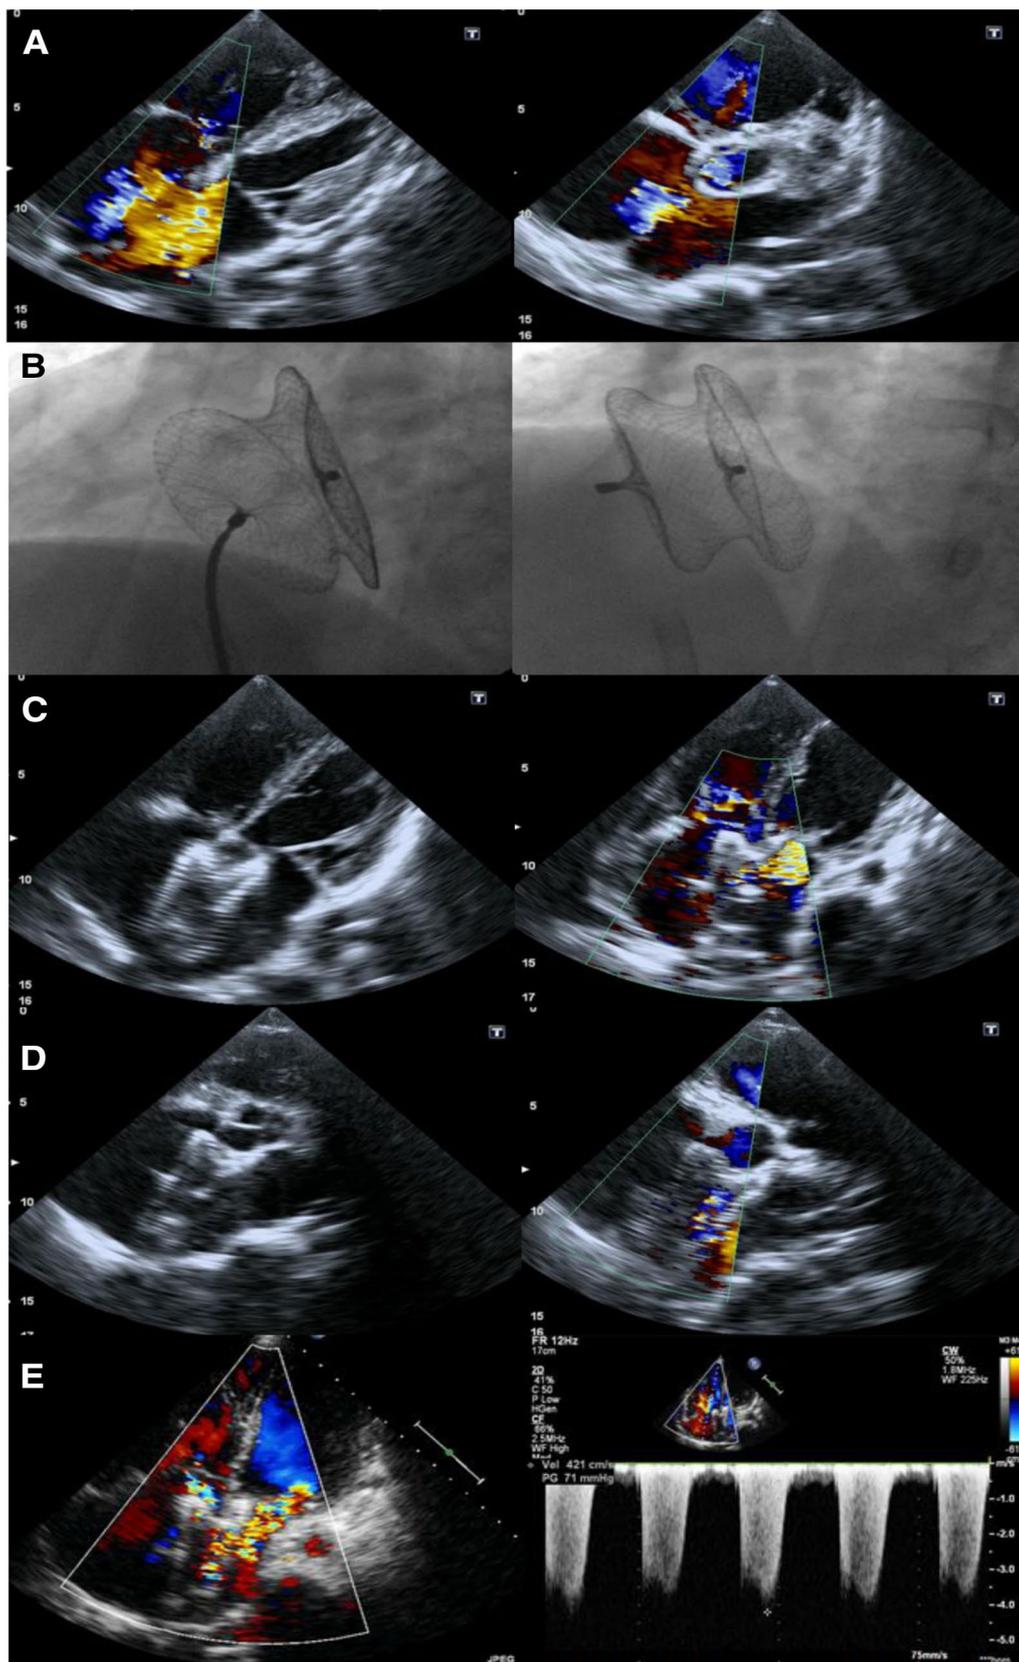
a Echo demonstrating ASD before the closure. b Angiogram shows atrial septal occluder. c, d Intraoperative echocardiography showed the proper position of the occluder. e Echo on day 3 after the procedure
